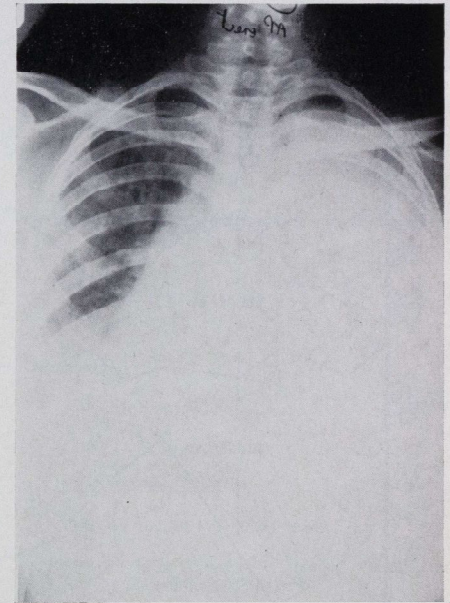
Chest X-ray on day of death showing a large left empyema with gross mediastinal shift.
